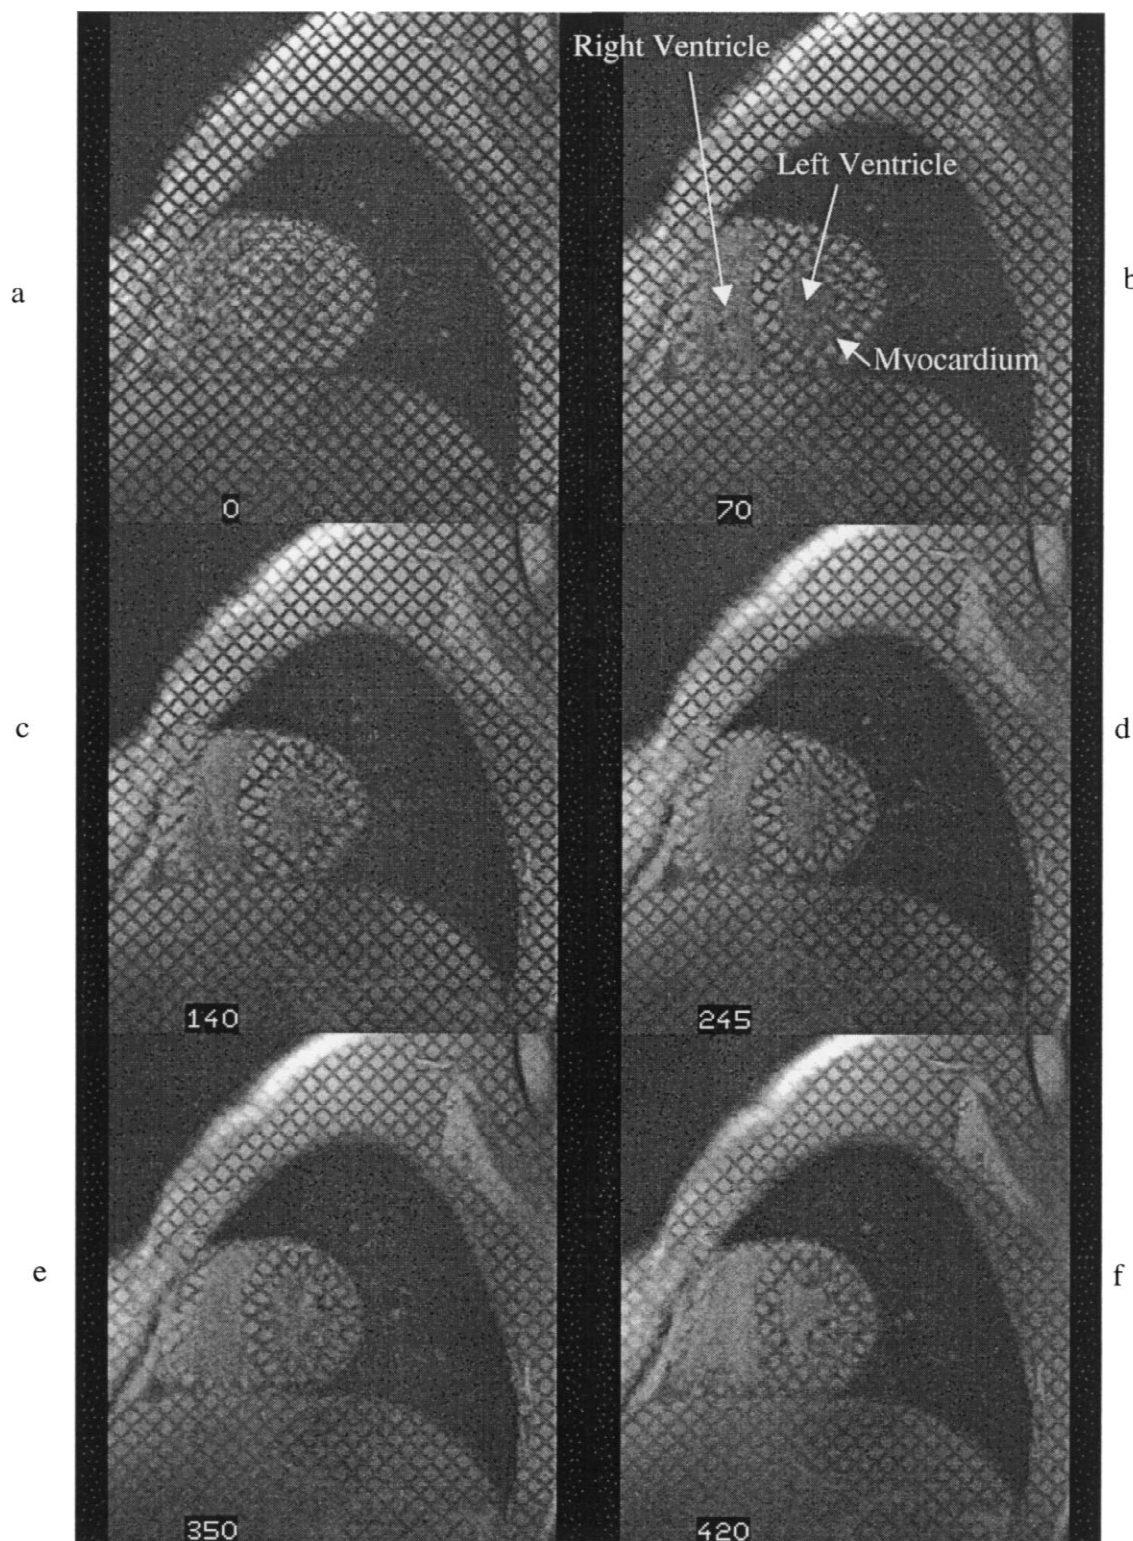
MRI SPAMM sequence of the heart (short axis views) from end-diastole (a) to end-systole (f). The initial tagging pattern (a) deforms to conform the myocardial motion. The tagging pattern is extracted and processed to compute the displacement field inside the myocardium.
